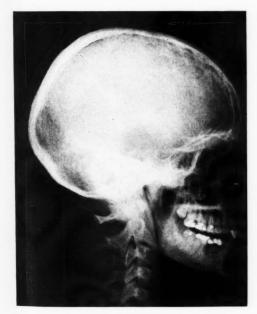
Osseous tissue profile roentgenogram.
